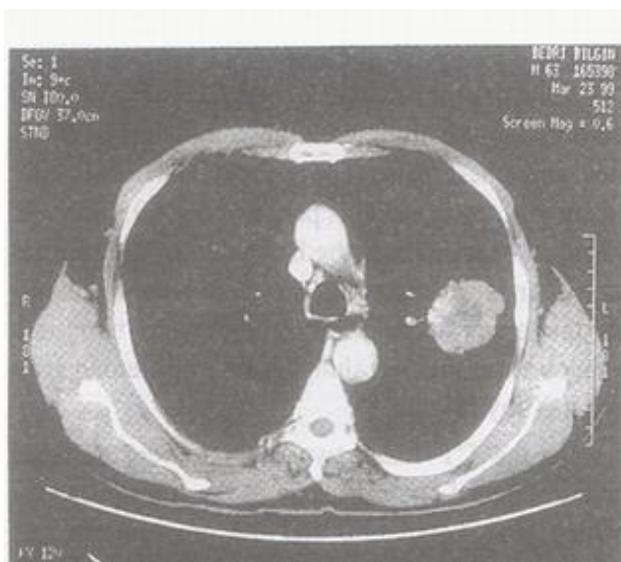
CT of the upper lobe tumor.
